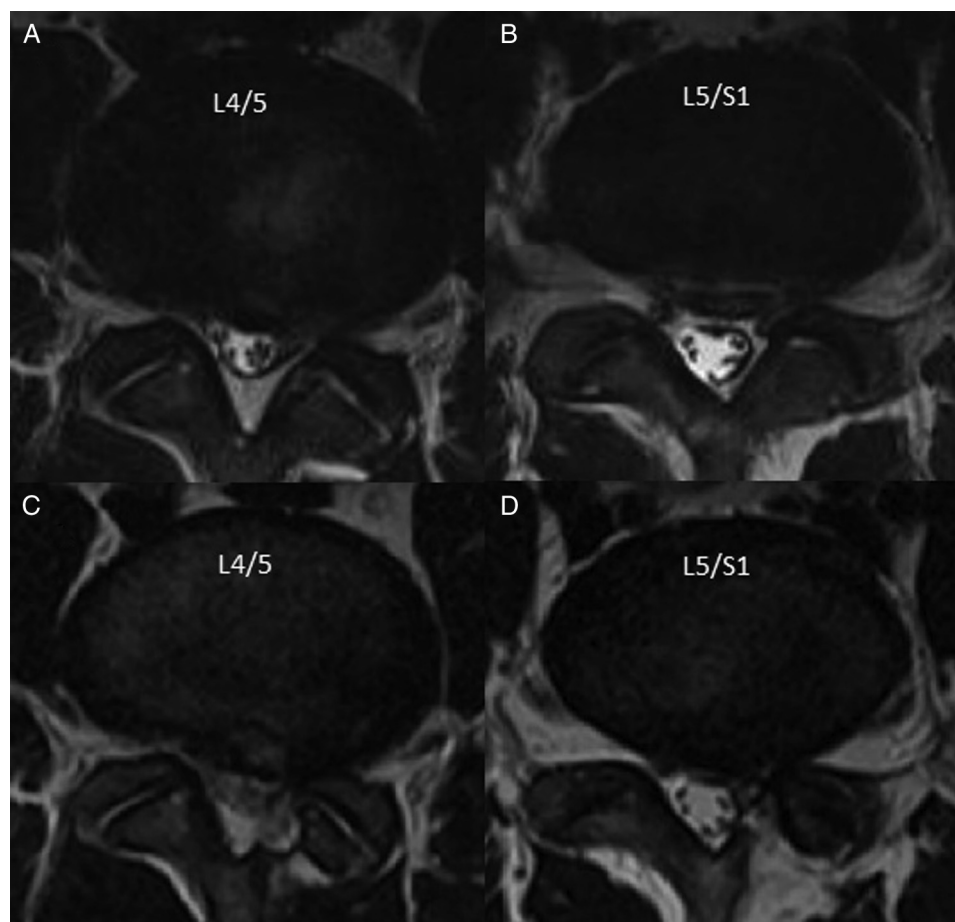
Lumbar spine magnetic resonance imaging scan in 2008 (A and B) and 2010 (C and D). Both L4-L5 and L5-S1 segments show left-sided lateral recess stenosis with impingement of the L5 and S1 nerve roots. The 2010 images showed recurrence of the prolapsed discs, causing stenosis of the lateral recess again.
